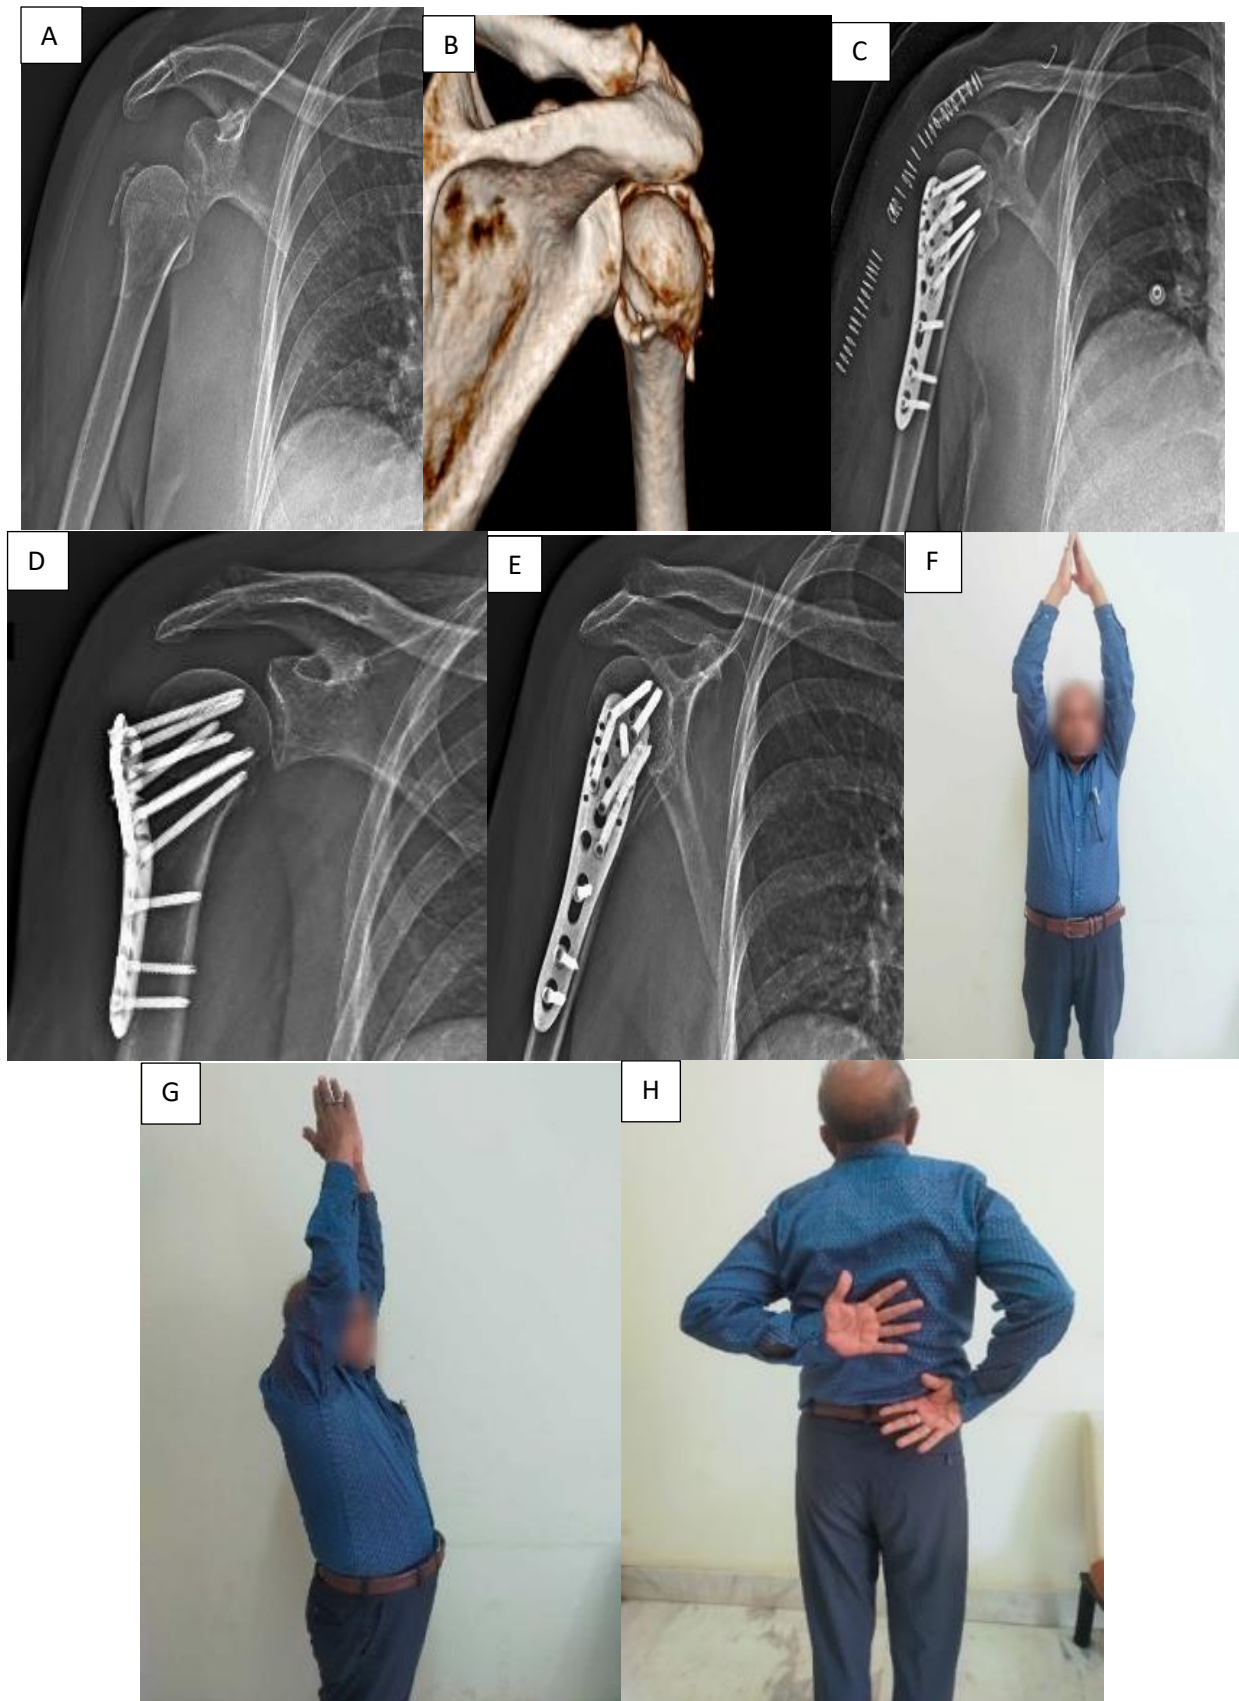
(A-B) 66 years old-pre op X-ray and CT 3d cut showing PHFD (Neer's 4 part); C- immediate post op X-ray; (D-E) X-ray at the end of 1 year showing good bony union; (F-H) Patient showing range of motion the end at the end of 1 year- He had restricted range of motion with a CMS score of 66.
